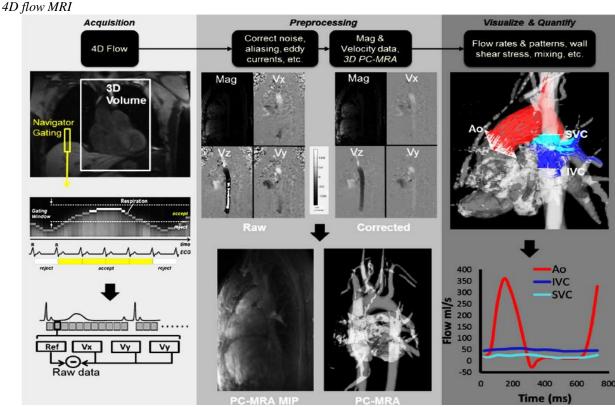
Research protocol and data collection for 4D motion MRI
